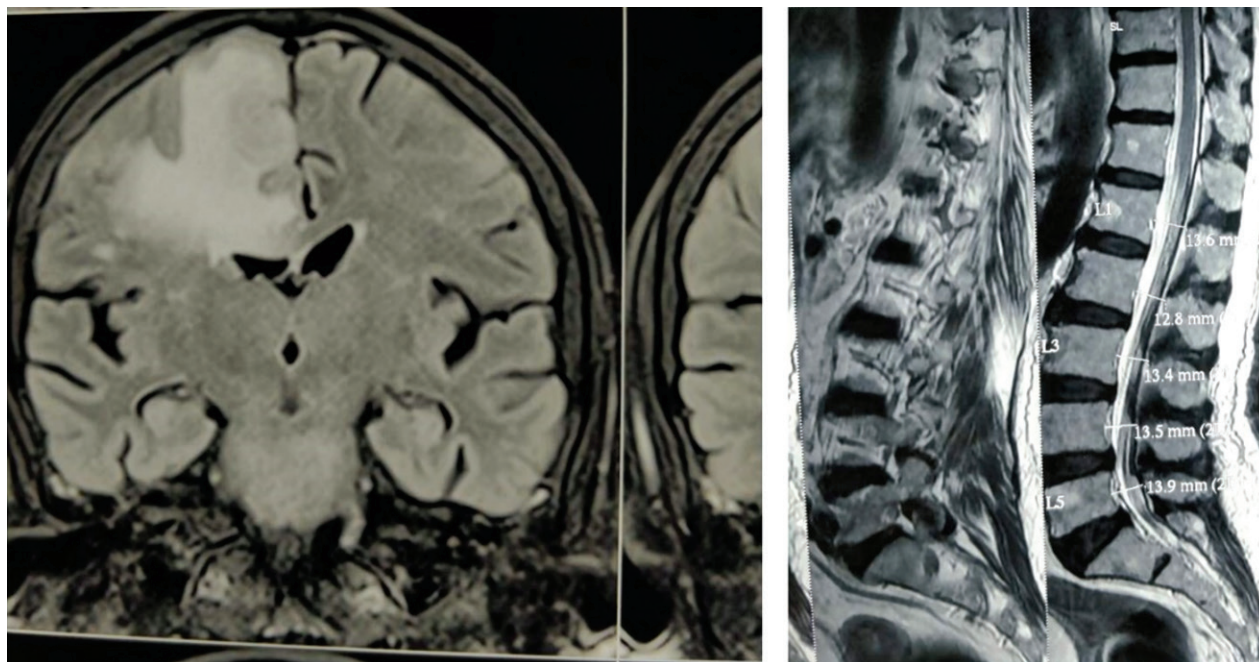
MRI Spine-T2 isointense lesion in prevertebral region at D12-L1level, degenerative changes in spine at L4-5 and L5-S1 level
